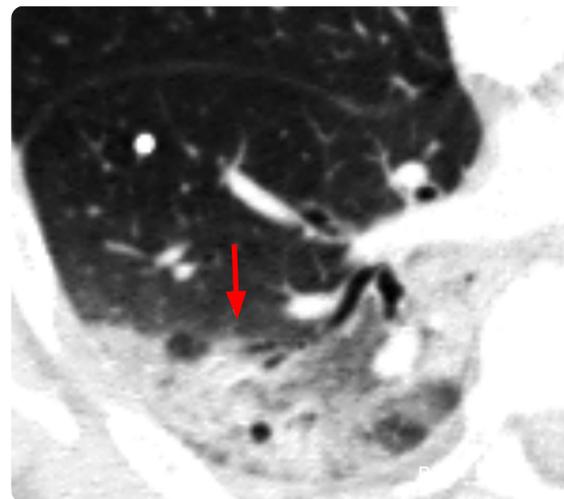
Axial thorax CT. 58-year-old patient, with suspicion of infection by COVID 19, which shows bronchial dilatation and thickening of the bronchial walls.
